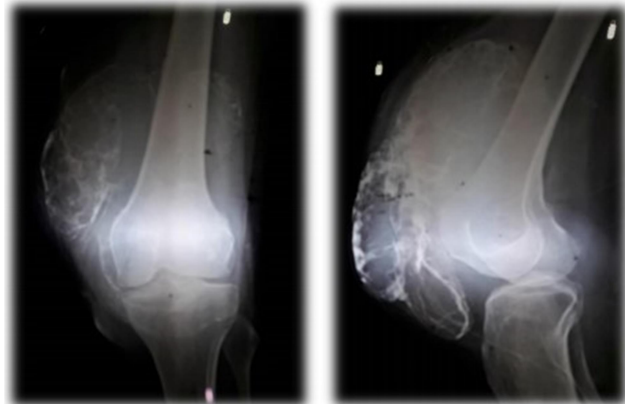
X-ray of right knee joint in anteroposterior and lateral views showing septate cystic patella with soft tissue extension in suprapatellar, infrapatellar, and medial region
